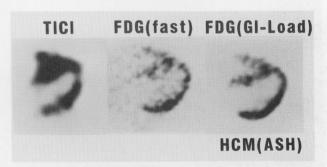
F-18-FDG fasting images in a 51-year-old man with ASH-type HCM, disclose generalized uptake, and the glucoseloading images normal uptake in the myocardium.
